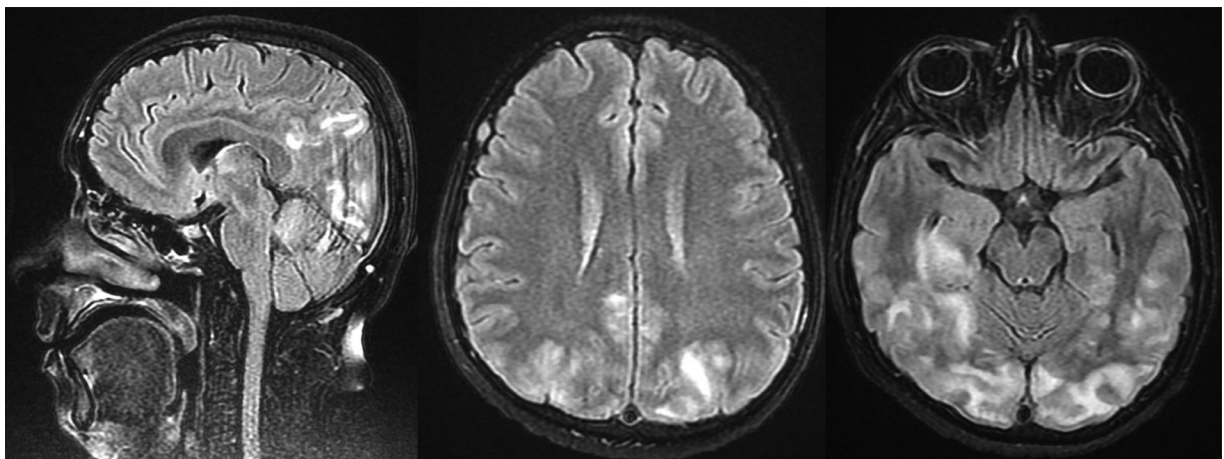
Sagittal and axial magnetic resonance FLAIR image demonstrating the lesions, mainly at prito-occipital and frontal region with no periventricular involvement.
